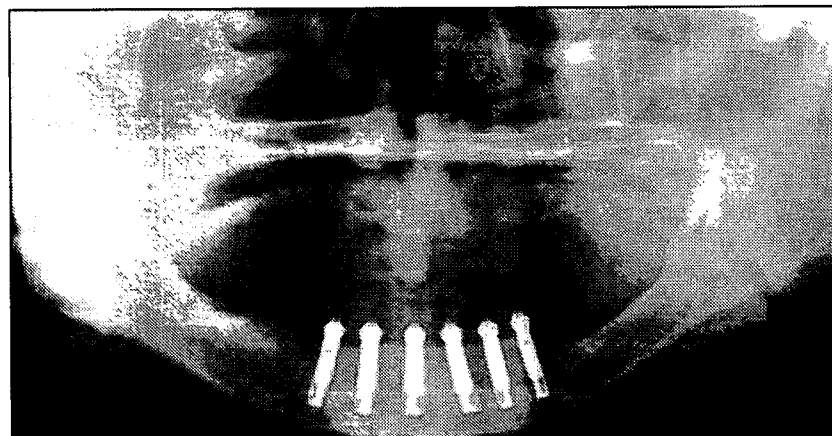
Radiograph obtained 1 year after seating the prosthesis.
